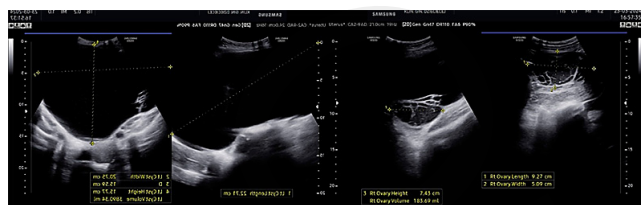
Ultrasonography (Case 1)
